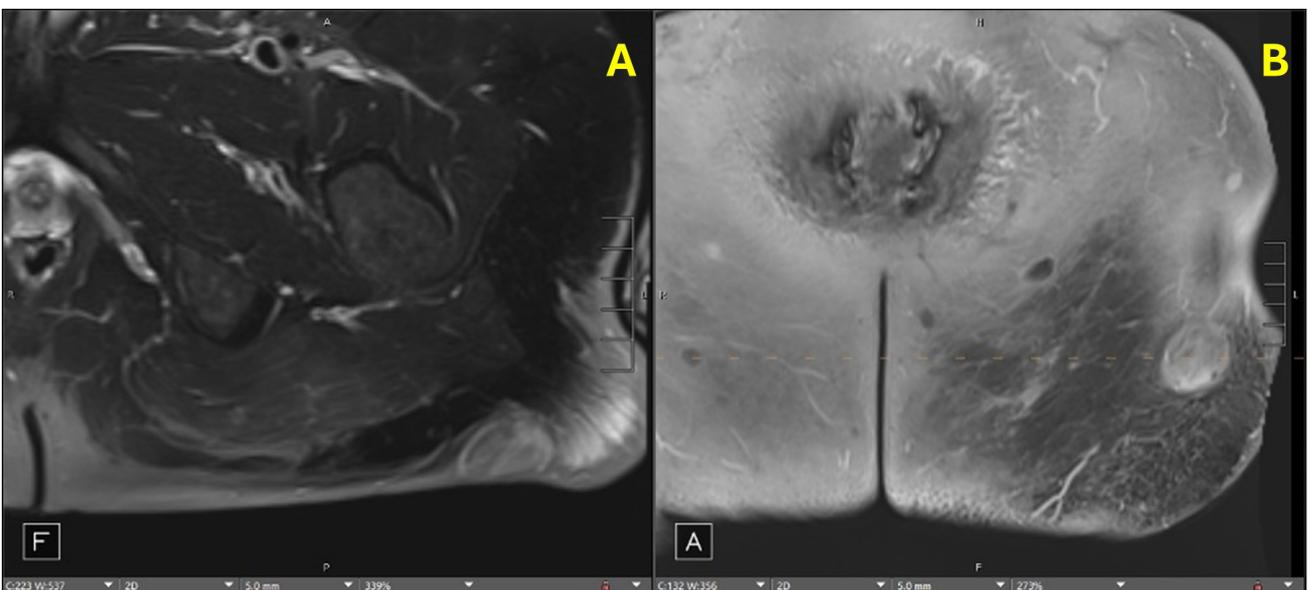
(A, B). Axial T1-weighted magnetic resonance imaging with contrast of the left lower extremity, which demonstrates a hyperintense lesion in the left lower limb compatible with a diffuse neurofibroma.
